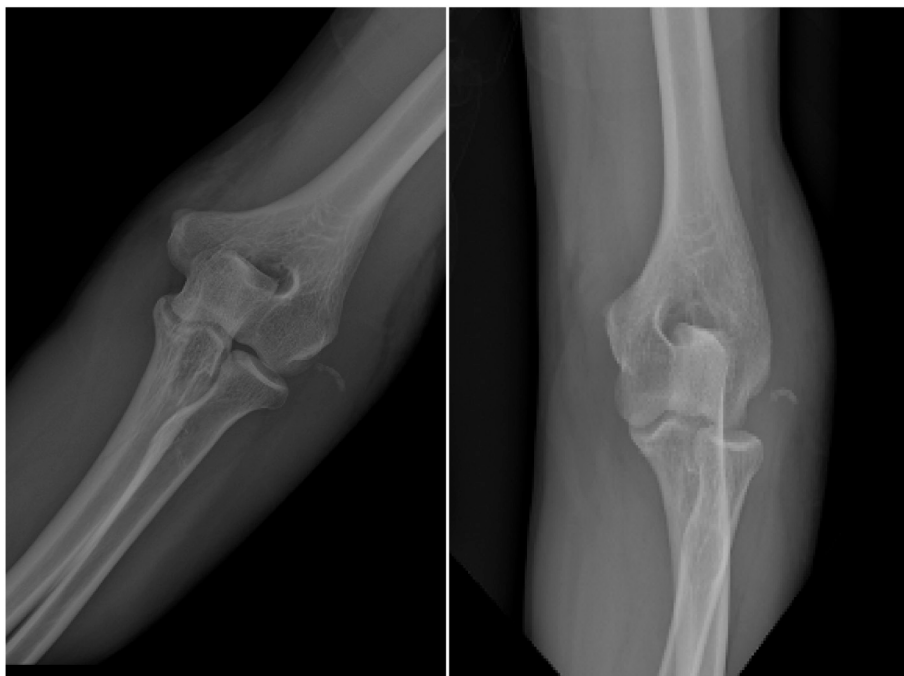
Preoperative plain radiographs.
